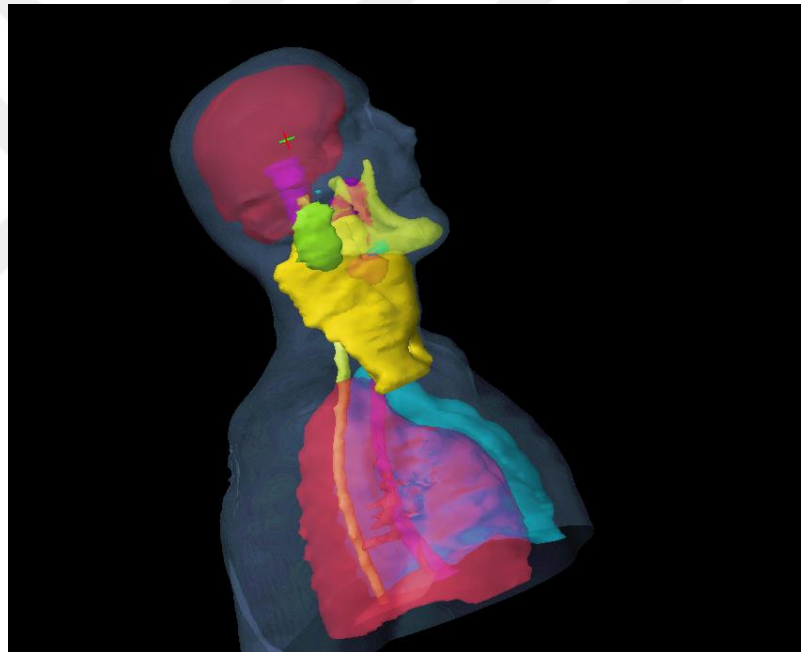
Contoured Critical Structures and Target Volumes on CT Images
